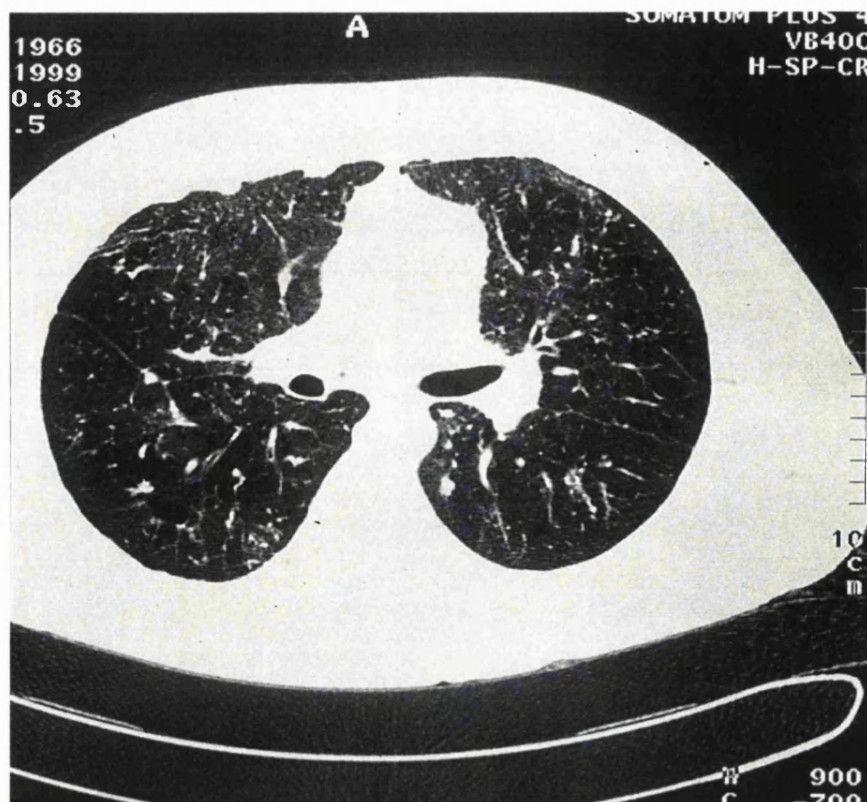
Fibrosis and scarring on CT scan
